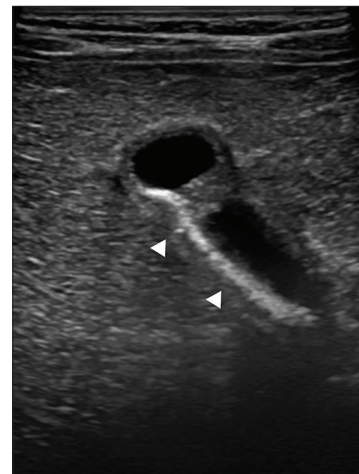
Ultrasound revealed a residual amount of biliary sludge (arrowheads), considerably reduced when compared to previous examination
